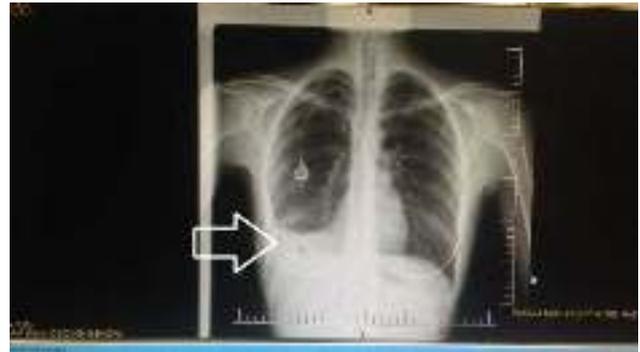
Admission x-ray showed right-sided pleural effusion
